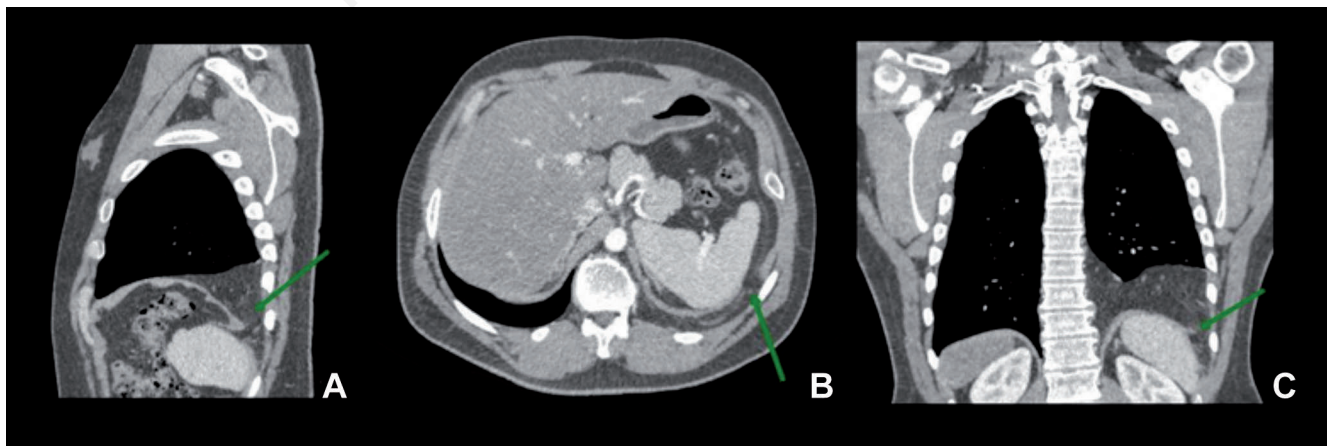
Computed tomography scan. The three sections (A, sagittal; B, axial; C, coronal) revealed a left sided herniation of abdominal contents (omental fat) into the thorax. The green arrows show discontinuity of the soft tissue lines of the diaphragm.
